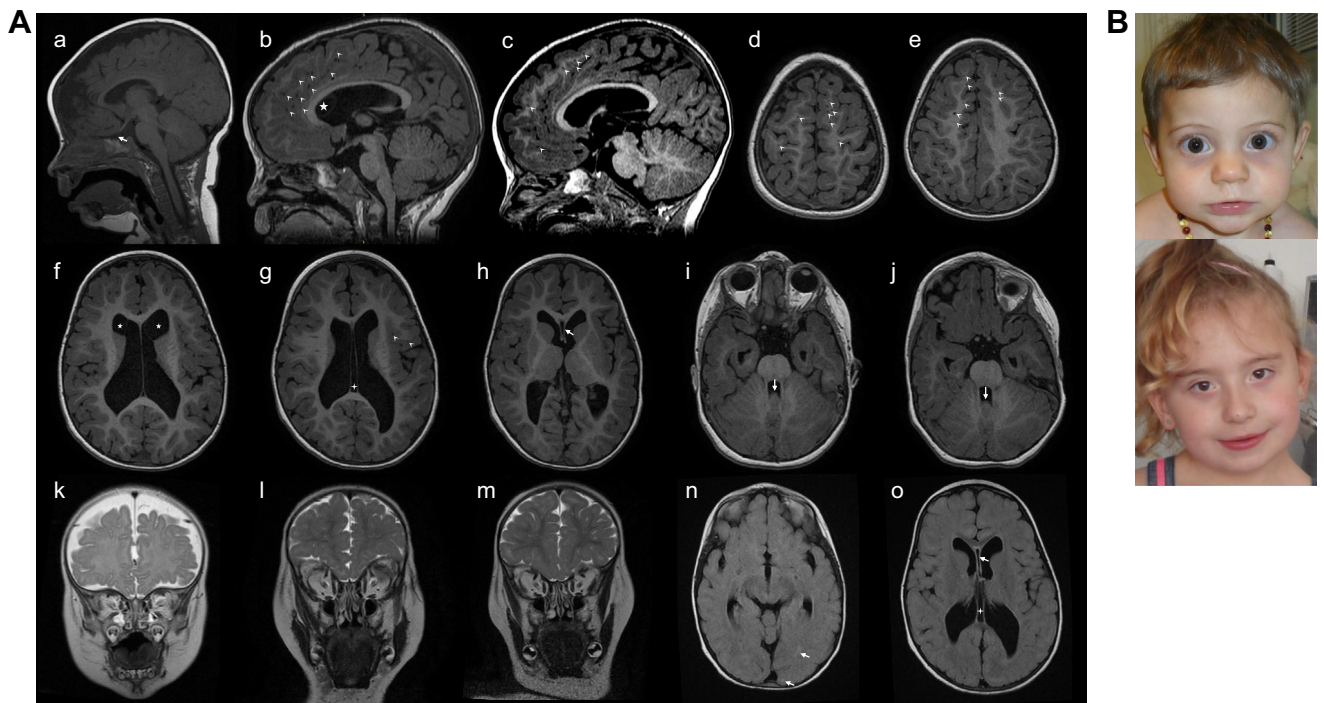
Brain MRIs and photographs in patients. A. Brain MRI images of cases 1 (at 6 months old), 2, and 3 (at 3 years old). (a-c) T1-weighted sagittal brain MRI. (a) Case 1: pituitary hypoplasia (arrow). (b) Case 2: ventricular dilatation, enlarged Virchow-Robin spaces (arrowheads), germinolytic cysts (star), and thin corpus callosum. (c) Case 3: ventricular dilatation, enlarged Virchow-Robin spaces (arrowheads), and thin corpus callosum. (d-j) T1-weighted axial brain MRI. (d) Case 2: enlarged Virchow-Robin spaces (arrowheads). (e) Case 3: enlarged Virchow-Robin spaces (arrowheads). (f) Case 2: ventricular dilatation and germinolytic cysts (star). (g) Case 3: ventricular dilatation and septum pellucidum cyst (cross). (h) Case 3: ventricular dilatation and cavum vergae cyst (arrow). (i) Case 2: cerebellar vermis hypoplasia (arrow). (j) Case 3: cerebellar vermis hypoplasia (arrow). (k) T2 weighted coronal brain MRI in case 1: presence of the olfactory bulbs. (l) T2 Fast recovery fast spin echo weighted coronal brain MRI in case 2: absence of the olfactory bulbs. (m) T2 Fast spin echo weighted coronal brain MRI in case 3: absence of the olfactory bulbs. (n-o) T2 Fluid-attenuated inversion recovery weighted axial brain MRI. (n) Case 2: isointense white matter, with loss of gray/white dedifferentiation and hypersignal of the posterior white matter showing delayed myelination with age (arrow). (o) Case 3: isointense white matter, with loss of gray/white dedifferentiation showing delayed myelination with age, ventricular dilatation, septum pellucidum (cross), and cavum vergae cysts (arrow). B. Photographs of cases 4 and 10 from top to bottom. *MRI*, magnetic resonance imaging.
